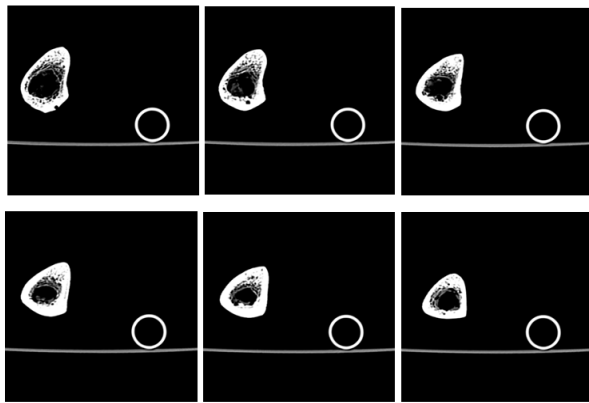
Six CT images of the tibia.
